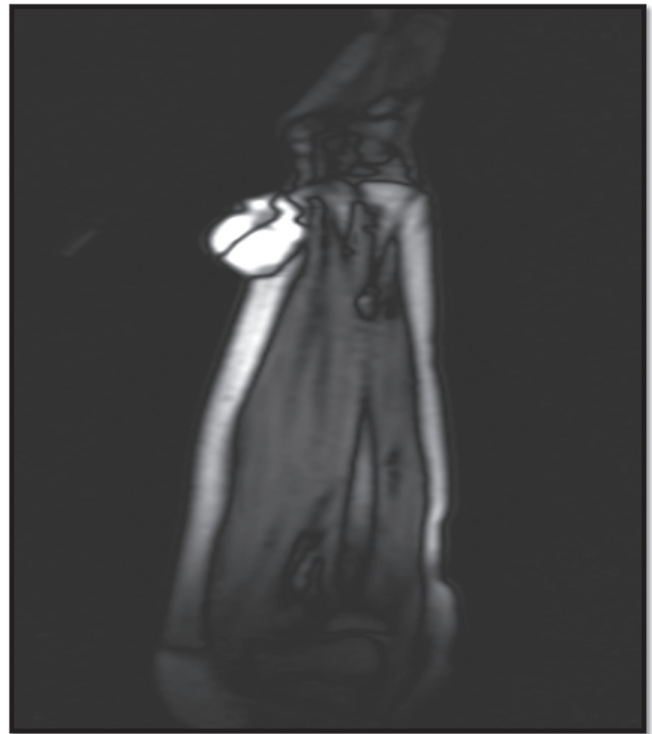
Case 3 MRI of soft tissue swelling of forearm
